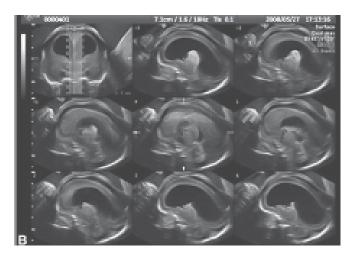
to D: Bilateral cleft lip at 35 weeks. Bilateral cleft lip is often overlooked because of its symmetrical facial structure. (A and B) 3D ultrasound shows the clear visualization of the bilateral cleft lip; (C and D) Postnatal facial appearance of the same baby
